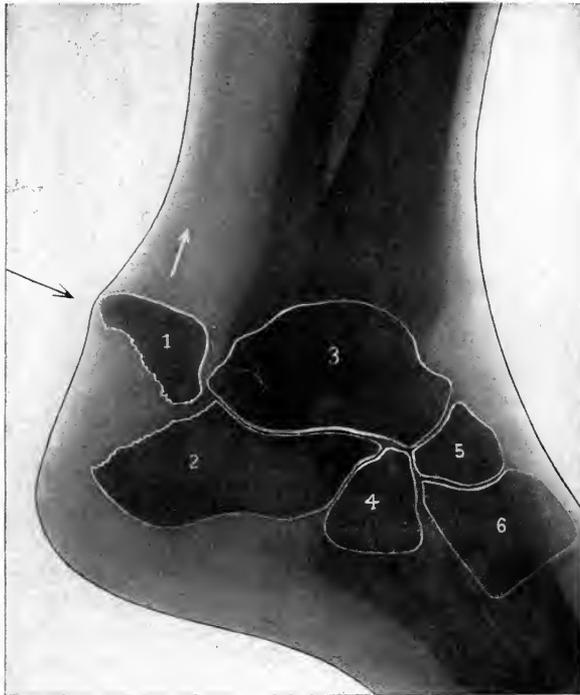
FRACTURE OF OS CALCIS (X-RAY) BY MUSCULAR VIOLENCE.
